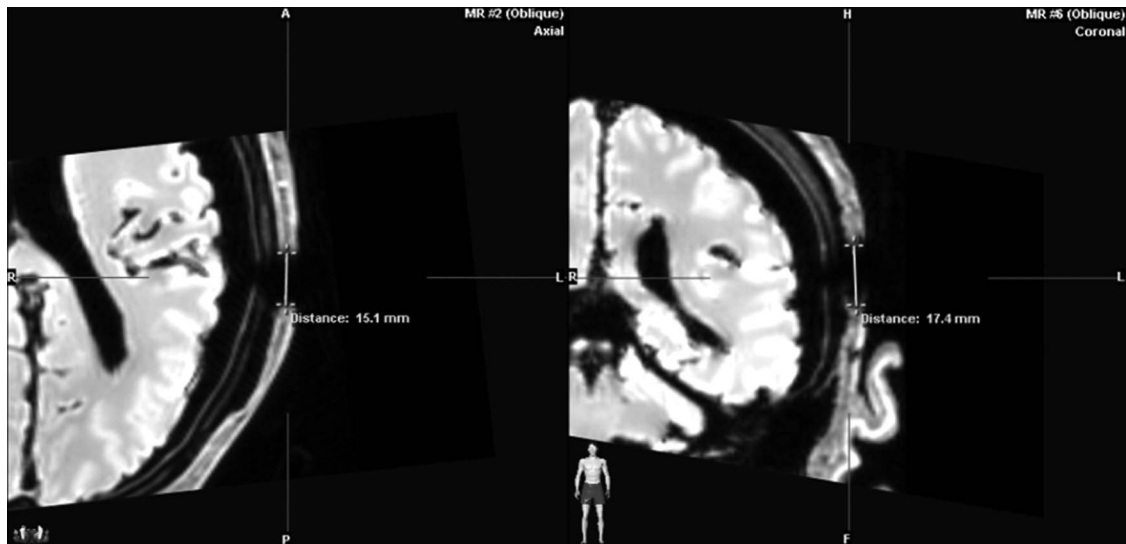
“Black hole” type artifact in magnetic resonance imaging including the dura (left, axial; right, coronal).
